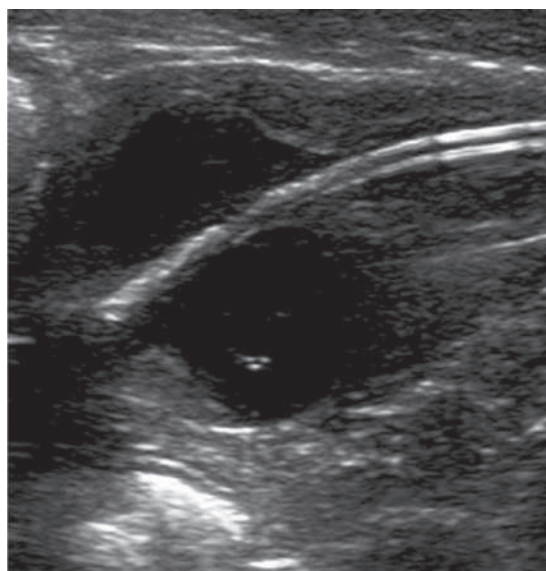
Abdominal ultrasonography revealed the presence of a double-lined linear structure with a hyperechoic margin within the bladder and cranial urethra.
